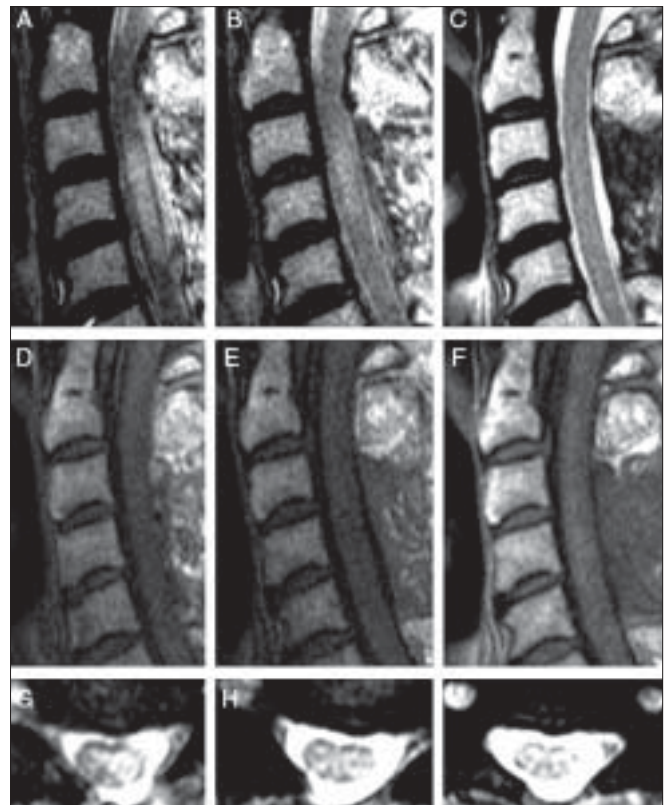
Sagittal view on T2- and T1-weighted MRI images and axial view on T2-weighted MR images one day (A, D and G), one week (B, E and H) and two months (C, F and I) after surgery
